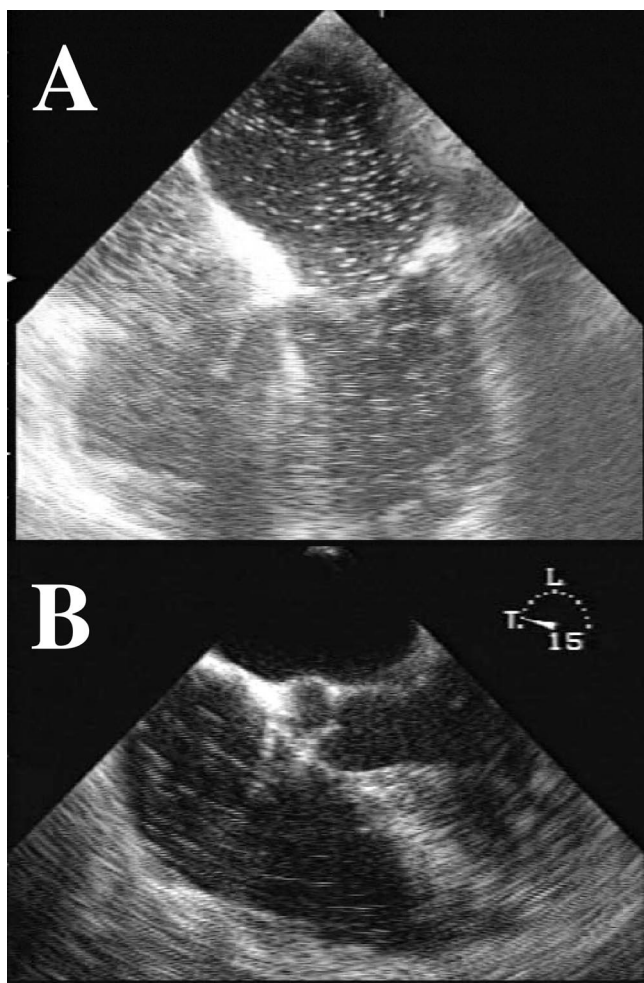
Representative transesophageal two-dimensional echocardiographic images depicting intracardiac gas-like bubbles defined as hyperechoic dots. (A) During microwave coagulation therapy, many gas-like bubbles were detected in not only the right but also the left atrium and ventricle in this patient. (B) Radiofrequency ablation caused numerous gas-like bubbles in the right atrium and ventricle.
